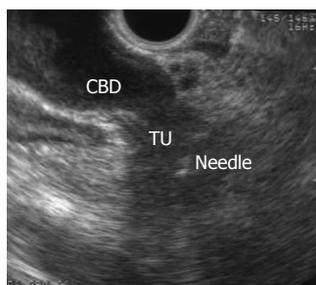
Endoscopic ultrasound guided fine-needle aspiration of pancreatic mass in a patient with painless jaundice.
